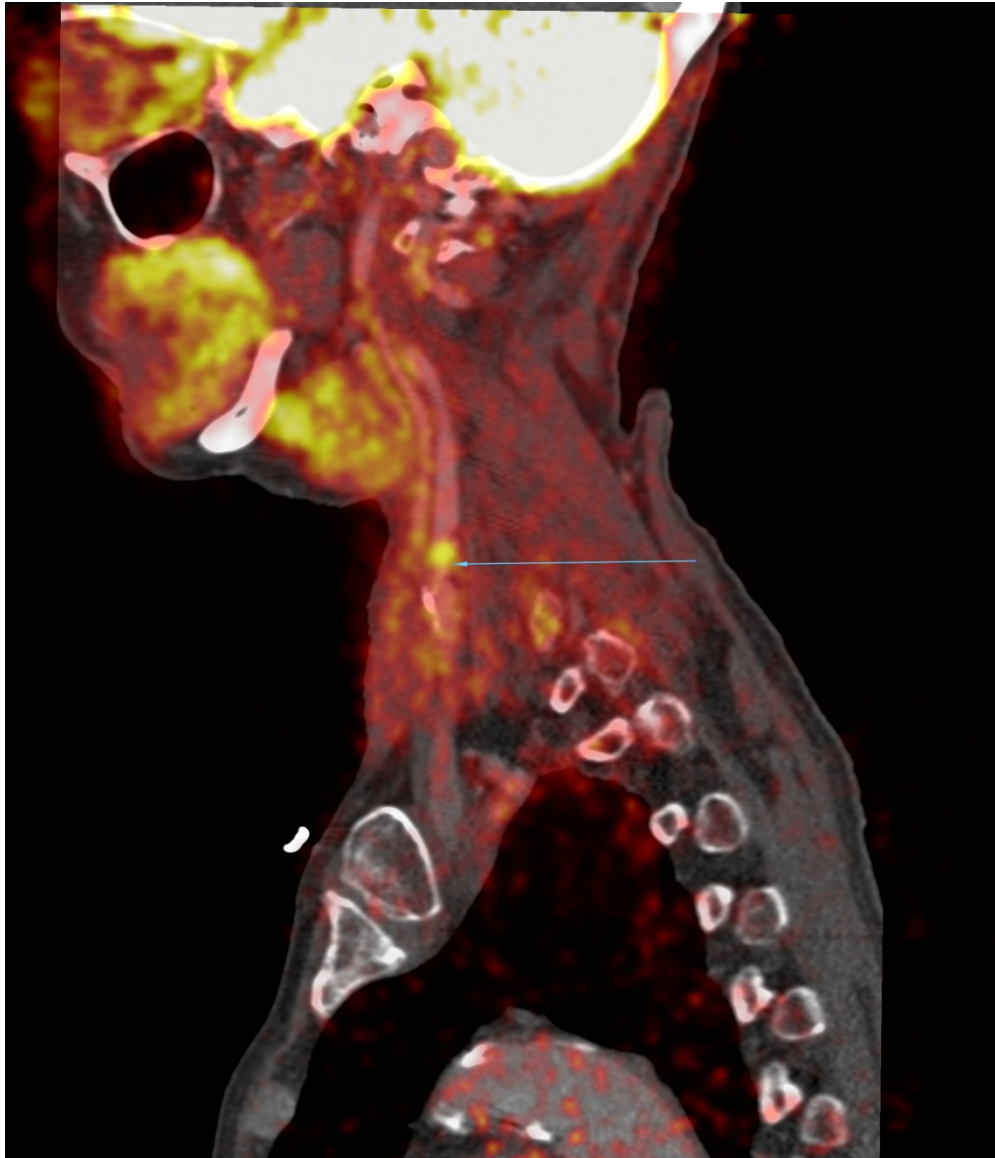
(b): Co-registered ^{18}F -FDG PET-CTA of same patient shows increased focal FDG-uptake in the region of the carotid plaque.
